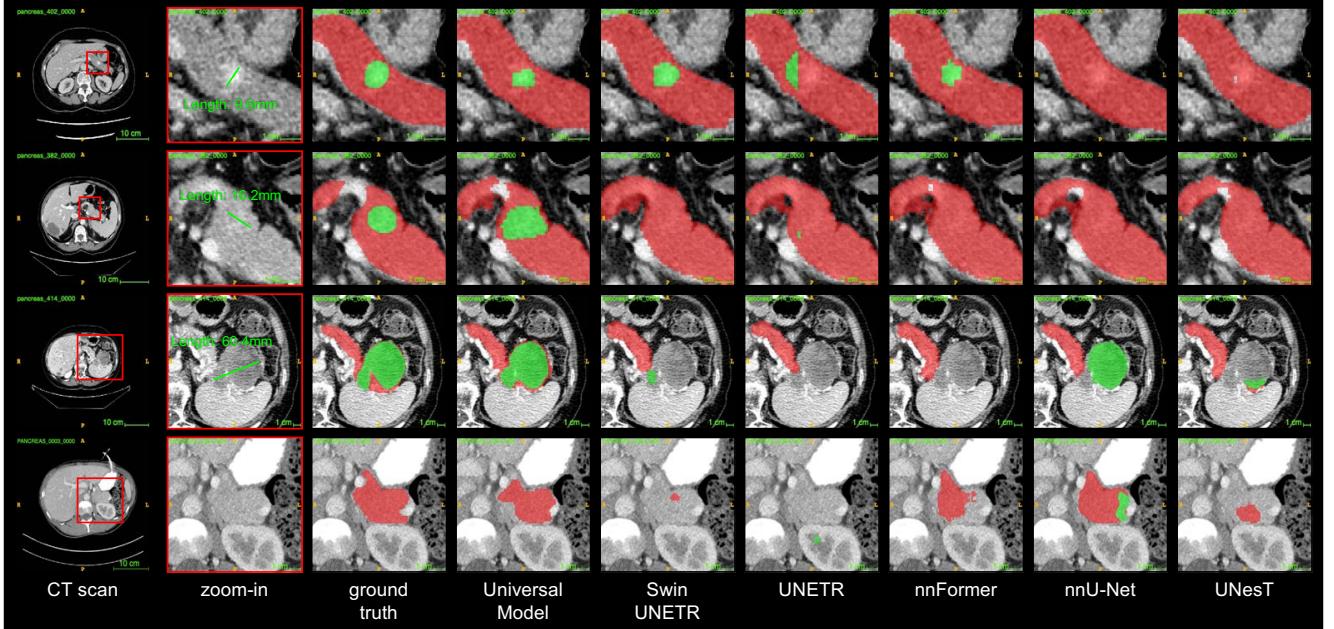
Pancreatic tumor detection. Qualitative visualizations of the proposed Universal Model and five competitive baseline methods. We review the detection results of tumors from smaller to larger sizes (Rows 1–3). When it comes to a CT scan without tumor from other hospitals, the Universal Model generalize well in organ segmentation and does not generate many false positives of tumors (Row 4; §4.2). The visualization of tumor detection in other organs (*e.g.*, liver tumors and kidney tumors) can be found in Appendix Figures 10–11.
